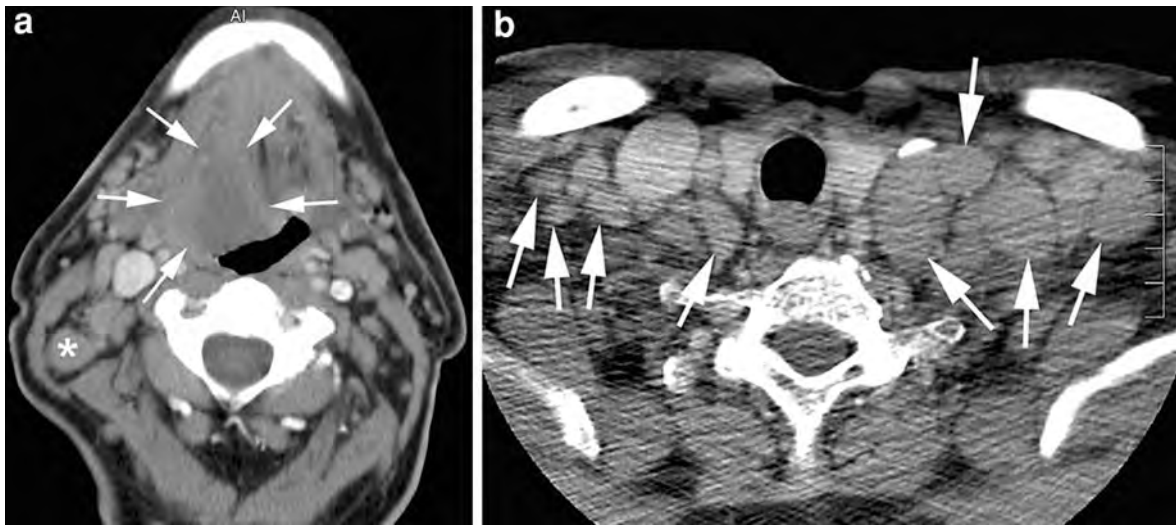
Axial contrast-enhanced CT-images. a Infiltrating soft tissue mass (*arrows*) in the right tongue base. Ipsilaterally, a slightly enlarged lymph node is seen in level II (*asterisk*). Several of such lymph nodes were seen throughout both sides of the neck. b Bilaterally in the neck base, homogeneous
